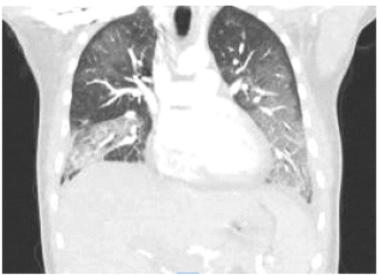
Computed tomography scan showing bilateral ground-glass opacities in a patient with EVALI, a hallmark diagnostic feature. Reproduced from: Acharya et al. [15].
